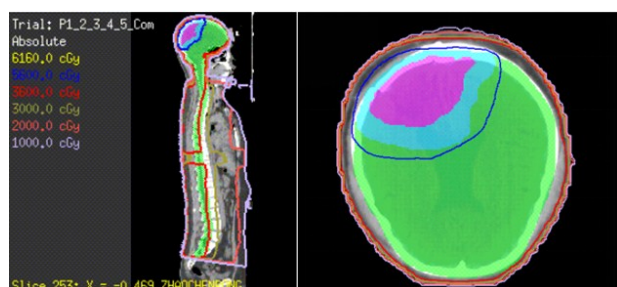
Radiotherapy planning CT (Treatment Planning System, Monaco). The planning target volume (PTV) of CSI (green color wash image) was administered 36 Gy (shown in red isodose line). The planning gross tumor volume of the tumor bed (PGTVtb) (baby blue color wash image) was administered 54 Gy (shown in blue isodose line). Note: The gross tumor volume of the tumor bed (GTVtb (rose red color wash image) with a margin of 1cm in three dimensions formed the Clinical Target Volume (CTV); CTV with a margin of 0.3 cm in three dimensions formed the PGTVtb.
